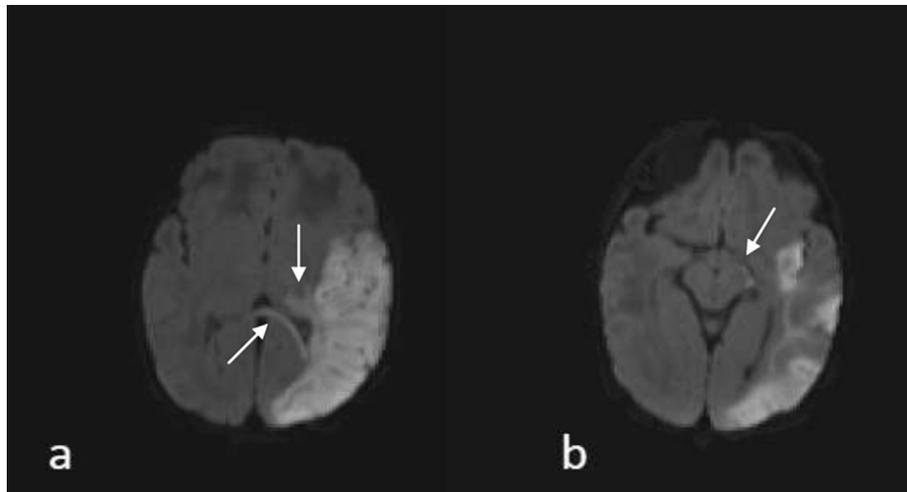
Diffusion Weighted MRI of a 4-day-old neonate with hypotonia and right focal seizures. The images are consistent with a left superficial median cerebral artery infarct. a) Network injury is visible at level of the pulvinar and the splenium of the corpus callosum; b) Restricted diffusion on the left cerebral peduncle suggests early wallerian degeneration.
